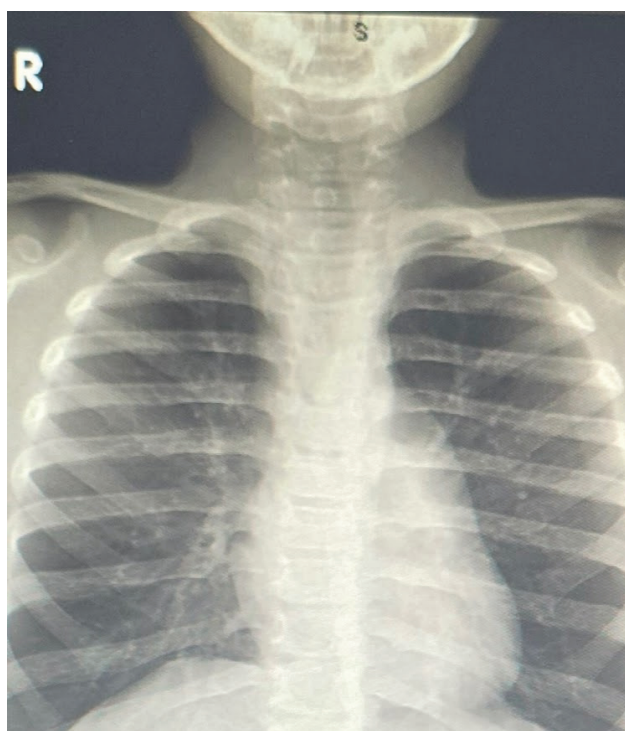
Chest X-ray showing right peri-hilar infiltrates.
